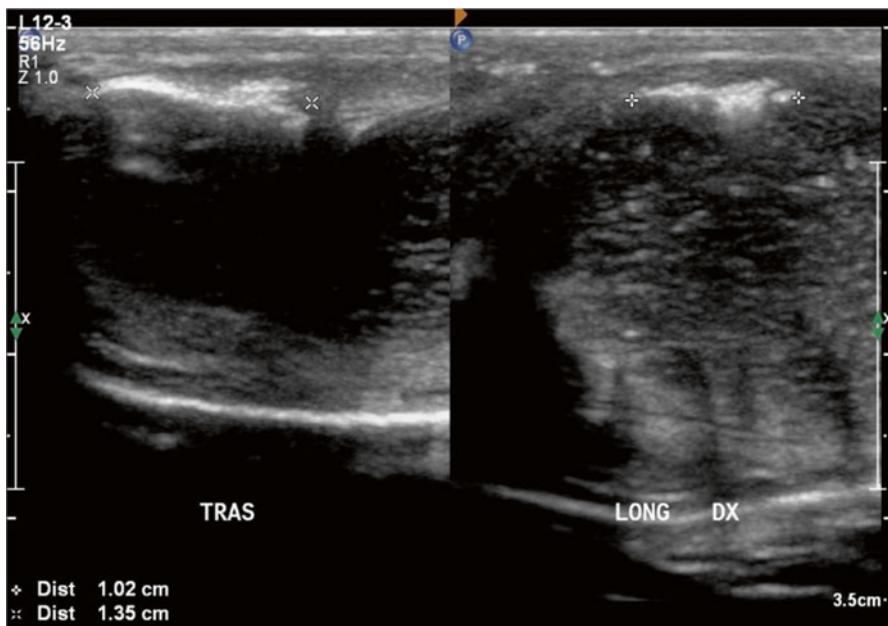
Penile plaque due to Peyronie's disease. Transverse and longitudinal sonogram demonstrates the dimensions of the plaque. Calcified plaque is noted involving the right corpus cavernosum and corpus spongiosum
